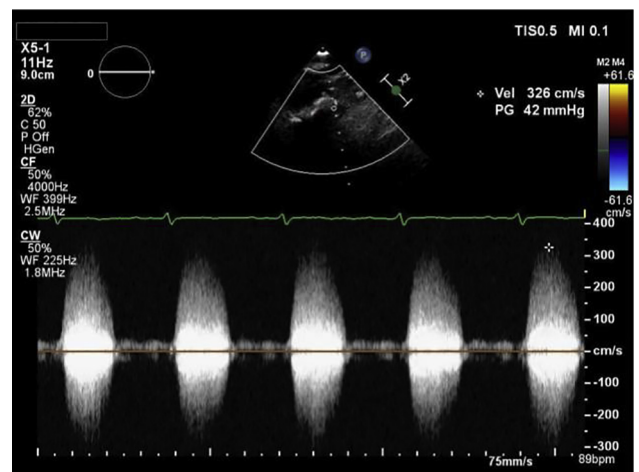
Continuous wave Doppler demonstrating a high gradient (> 40 mm Hg) across the brachiocephalic trunk in the suprasternal view on transthoracic echocardiography.
